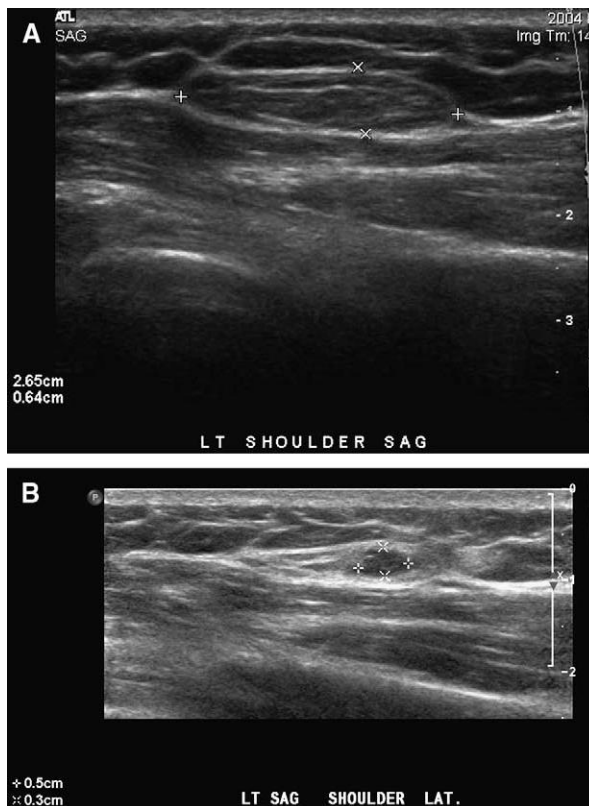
A, Ultrasound of lipoma 7 located on the shoulder measuring 2.65 × 0.64 cm before treatment. B, Same lipoma measuring 0.5 × 0.3 cm 4 months after second and last injection.
